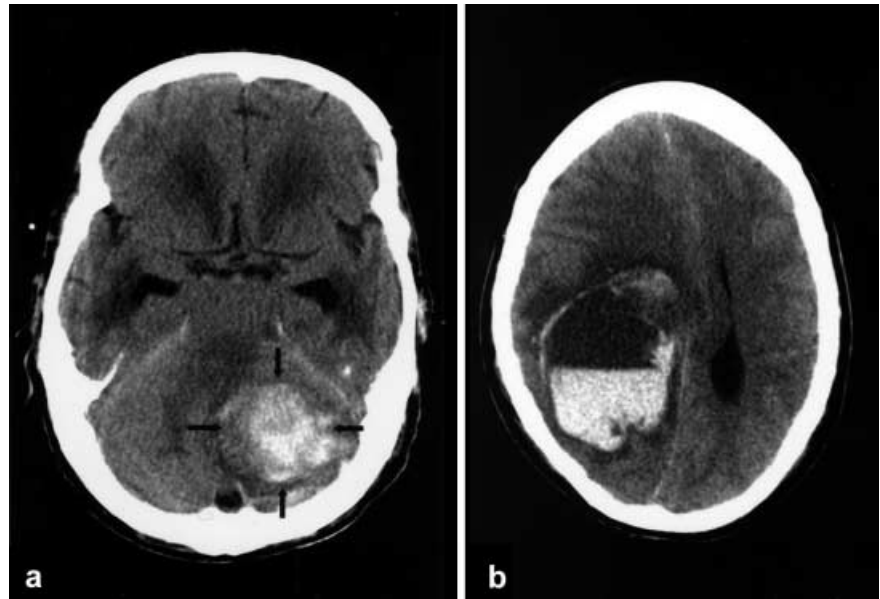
a Clinically silent cerebellar haemorrhage in a patient having follow-up CT after thoracotomy for pericardial tamponade. The patient was weaned from ECMO and the bleeding did not progress. b Large fatal intracranial bleeding in a young woman
